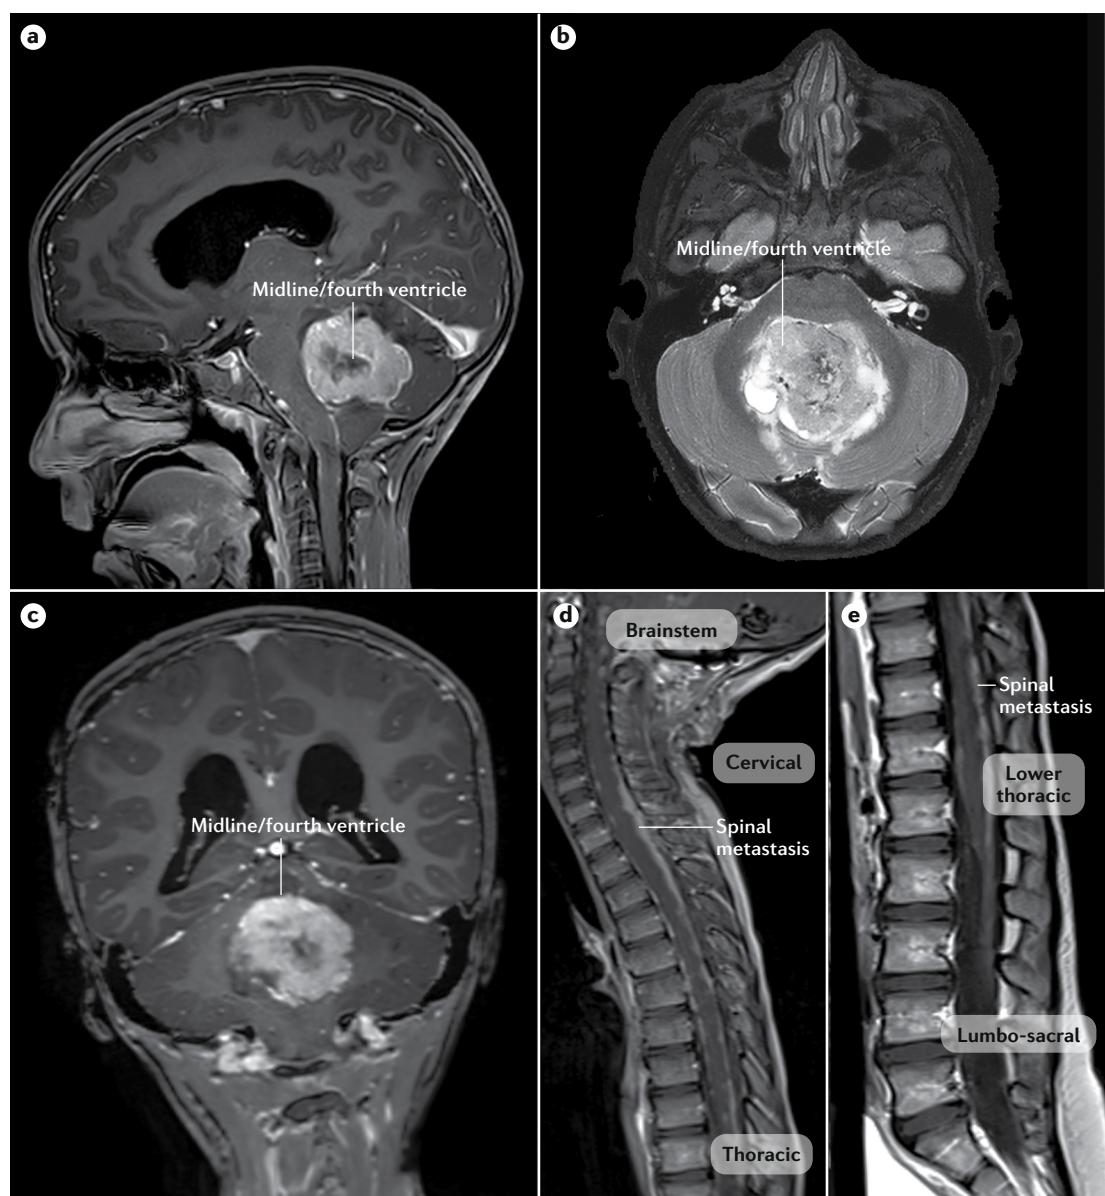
MRI of MB. a–c | Cranial MRI images of a patient with medulloblastoma (MB). Sagittal plane (part a), transverse plane (part b) and coronal plane (part c) are shown. d,e | Spinal MRI of patient after suboccipital craniotomy for tumour in the posterior fossa with multiple enhancing metastatic lesions within the spinal canal. These lesions indent the lower thoracic spinal cord and occupy much of the caudal thecal sac. Leptomeningeal disease is also present as streaks of white ‘sugar-coating’ outlining the cord and best seen along the anterior portion of the brainstem, lower cervical and lower thoracic cord.
